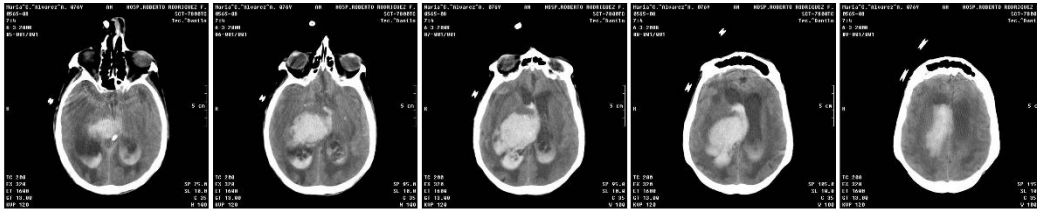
CT images of a spontaneous intracerebral hemorrhage (slides 5, 6, 7, 8 and 9)
